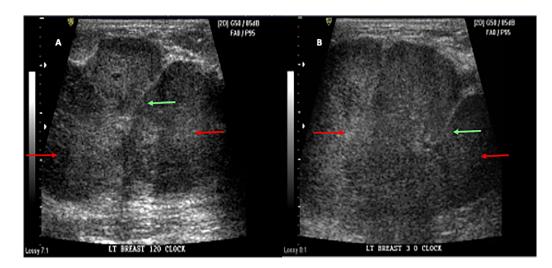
(Patient no. 1): Ultrasound of left breast at 12 o'clock (A) and 3 o'clock (B) shows multiple, solid, hypoechoic, partially circumscribed and partially coalescing masses, which are antiparallel in orientation (red arrows). The margins have a thin but echogenic rim (green arrows), posterior enhancement is seen but calcification is conspicuously absent.
